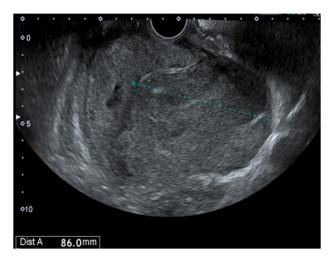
Trans vaginal sonography showing the enlarged uterine cervical mass (8.6 cm).
